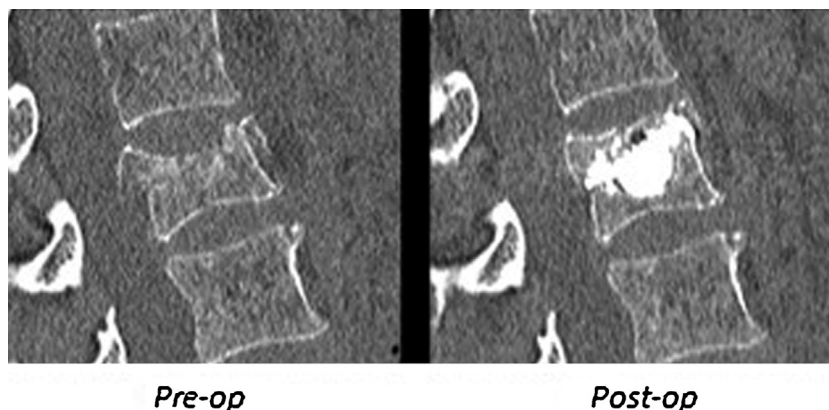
64-year-old woman with a post-traumatic type A3.1 fracture of L1. Computed tomography before and after the SpineJack® procedure.
